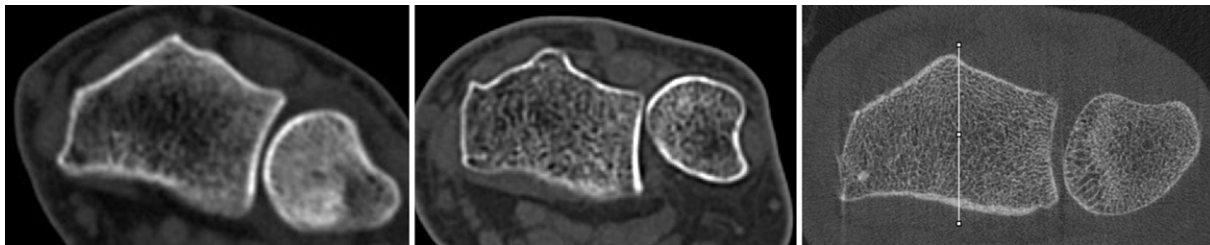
Comparison of spatial resolution of distal forearm. Left and center: CT of the forearm using whole body CT scanner, left: standard body reconstruction kernel; center: bone reconstruction kernel; right: HR-pQCT scan (images from different patients).
